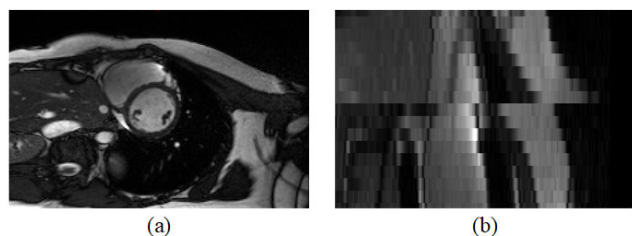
(a) Short-axis slice of cardiac MRI. (b) Cross section obtained by reconstructing multiple slices along the short axis. Note: Slice misalignment is due to different breath-holds during successive image acquisitions.
